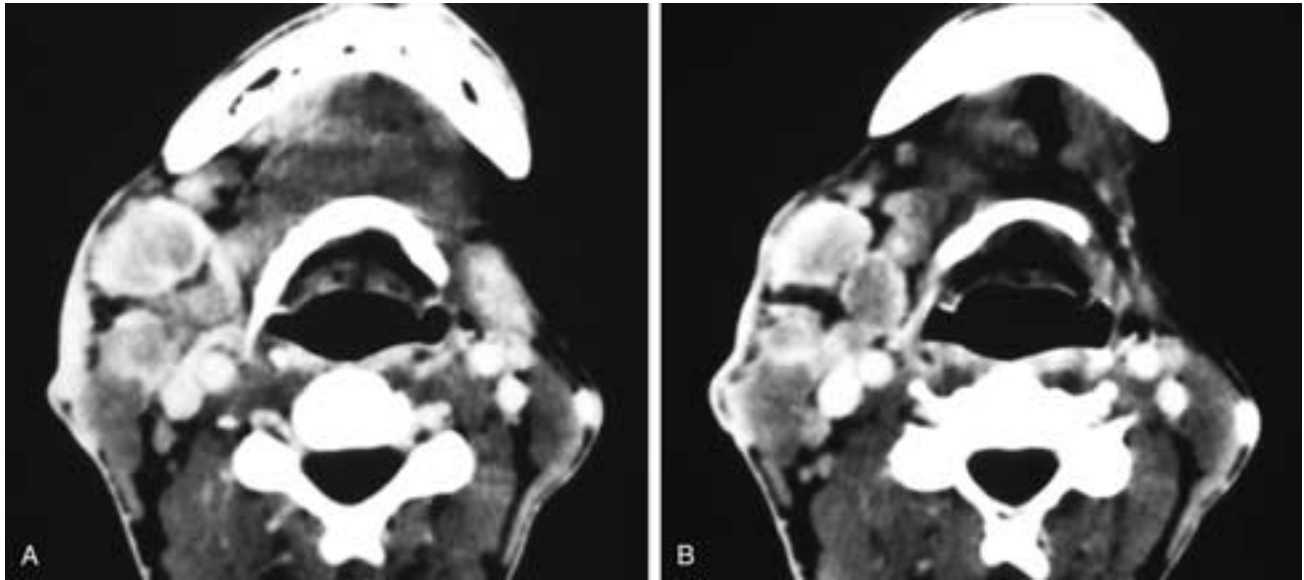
Axial CT scans from cranial (A) to caudal (B) show enlarged, enhancing, fairly homogeneous right level I and II nodes and a smaller left level II node. There is also thickening and enhancement of the adjacent skin in the right neck, and there is involvement of the right parotid gland in this Asian patient with Kimura's disease.
